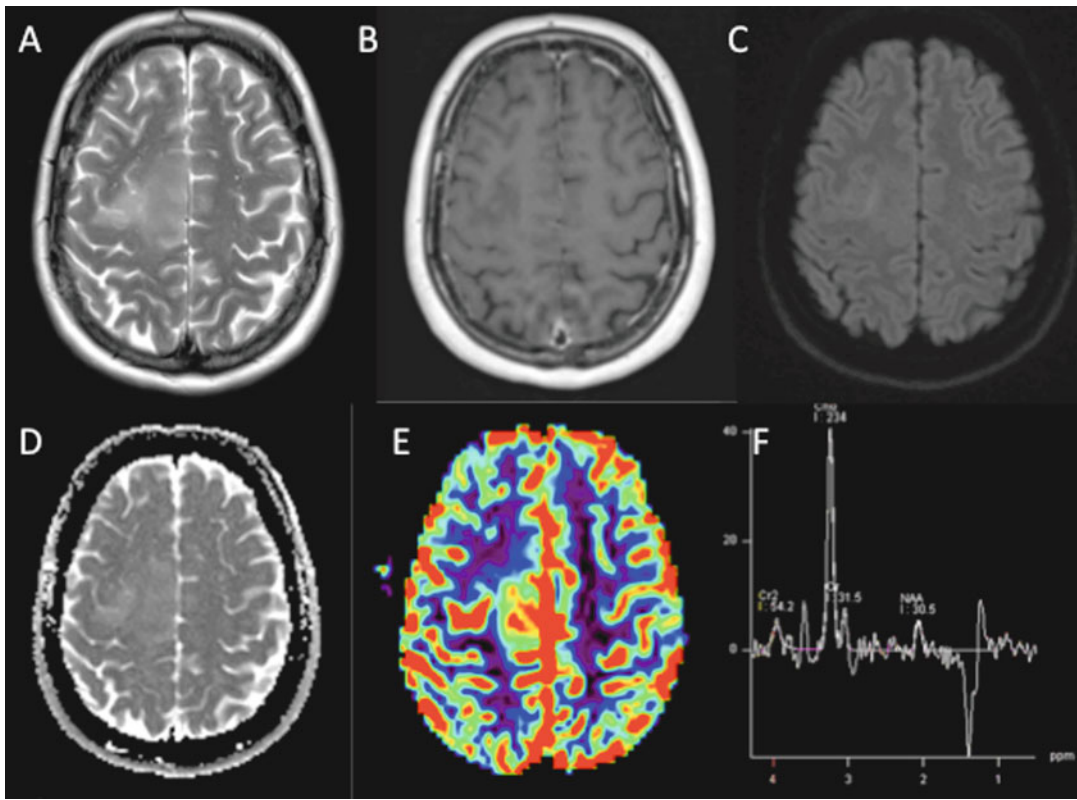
Value of advanced imaging for the identification of malignant glioma: T2w (a) and T1 + Gad images (b) demonstrate a non-Gadolinium-enhancing mass. DWI and ADC map (c, d), DSC perfusion (e) and MRS (f) reveal
